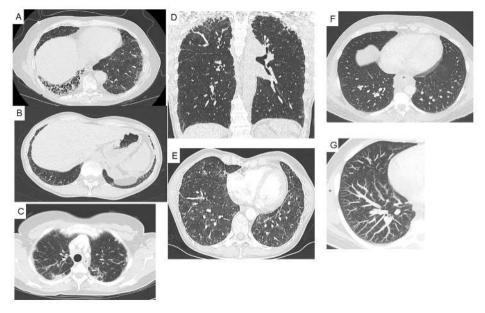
Computed-tomography of the chest in patients with pulmonary disease due to telomere-related gene mutations. (A) usual interstitial pneumonia (UIP). (B) possible UIP. (C and D) inconsistent with UIP suggestive of pleuro-parenchymal fibroelastosis. (E) ground glass opacities superimposed with fibrosis revealed to be secondary to pneumocystis infection. (F) normal chest CT scan in a patient with hypoxemia and liver disease. (G) reconstruction with maximum intensity projection revealed intrapulmonary vascular dilatation.
